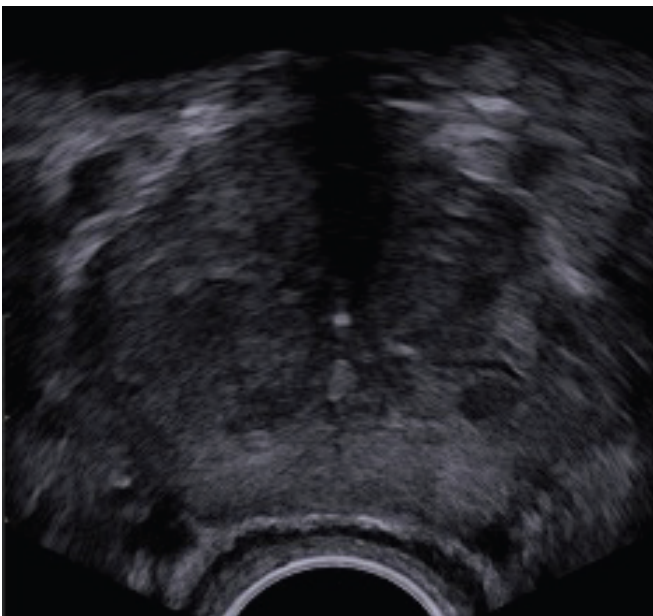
Transrectal ultrasound image of the prostate (axial view). (Image courtesy of Clement Orczyk).
